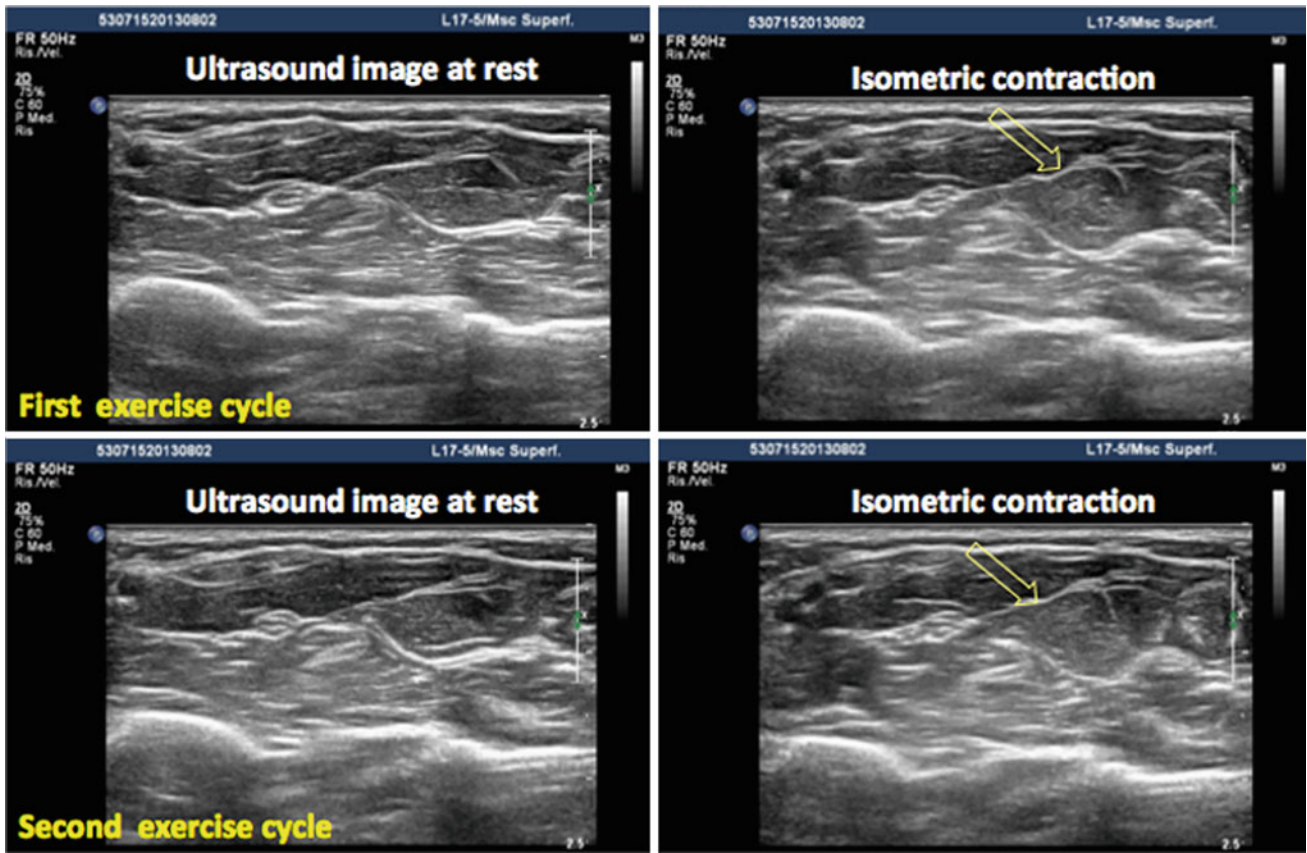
Examples of different forms of muscular contractions on real-time ultrasound examinations are demonstrated in the three video clips (isometric contraction, isotonic contraction, and passive stretching) which can be accessed and downloaded via www.extras.springer.com.
